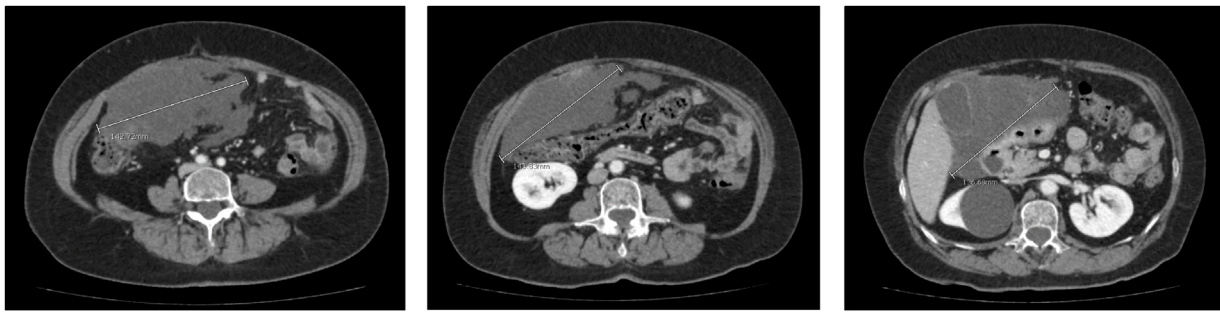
Axial CT imaging showed a large multi-cystic intra-abdominal mass in the right abdomen spanning from the porta hepatis to the right lower quadrant.
